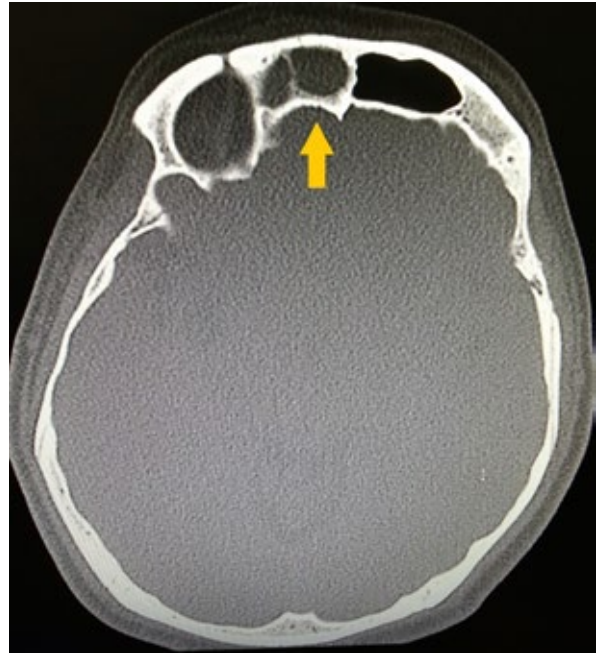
Axial view of the CT scan showing sclerosis of the surrounding bony structures of the right frontal sinus with dense soft tissue located inside (arrow)
